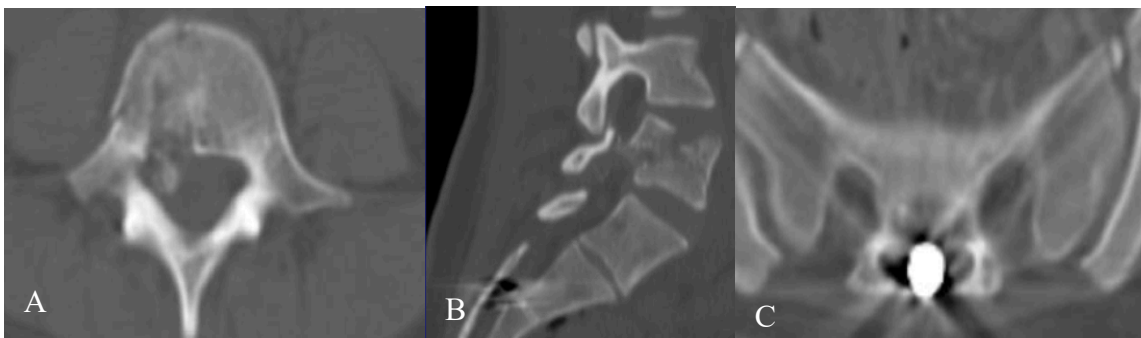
A,B: axial and sagittal CT scan showed fracture of right pedicle and wedge of L4. C: axial view showed intracanal bullet fragment in S2
